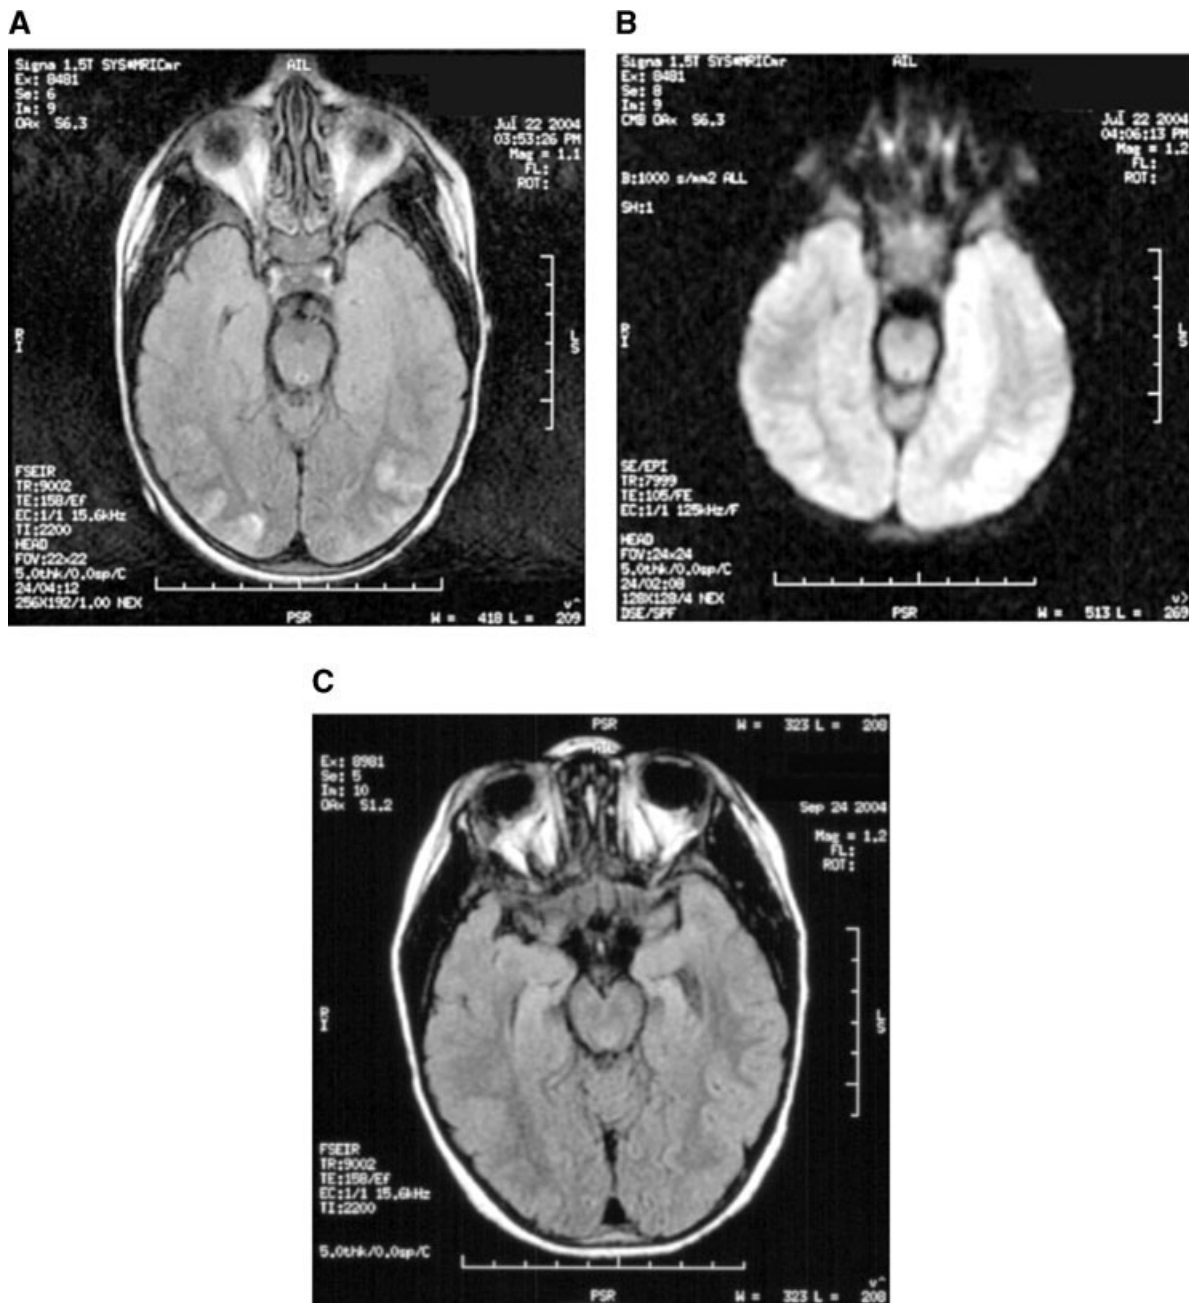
(MRI images): A: Initial T2-weighted FLAIR image with patchy subcortical T2 abnormalities in bilateral parietal and occipital lobes. B: Initial diffusion-weighted image that has some T2 shine-through, but is otherwise normal. C: Follow up T2 weighted FLAIR image at 2 months with resolution of the T2 changes.
